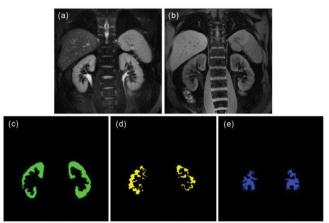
T2-weighted image (a) to separate the entire kidneys from the surrounding tissues. T1-weighted image (b) with adapted sequence parameters for a good contrast between renal cortex (c), medulla (d) and pelvis (e).
